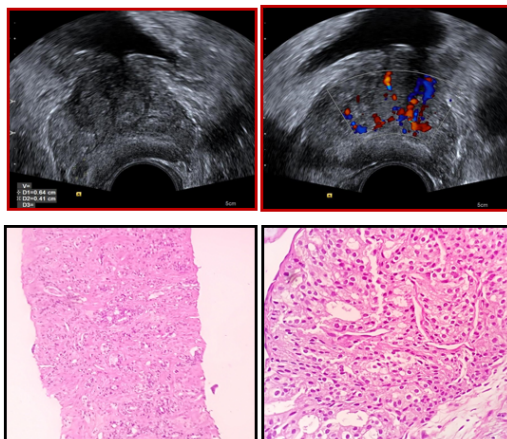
Transabdominal ultrasound showing heterogenous and irregular predominantly hypoechoic mass lesion in peripheral zone of prostate
